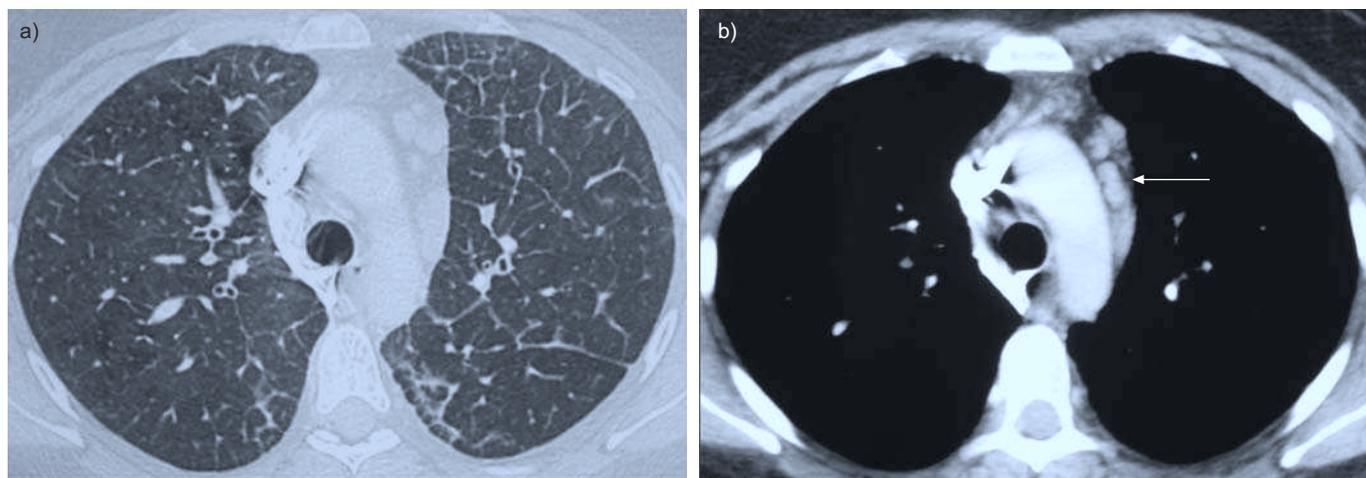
High-resolution computed tomography in a pulmonary veno-occlusive disease patient showing septal lines and ground-glass opacities (a) associated with mediastinal lymph node enlargement (arrow, b).
